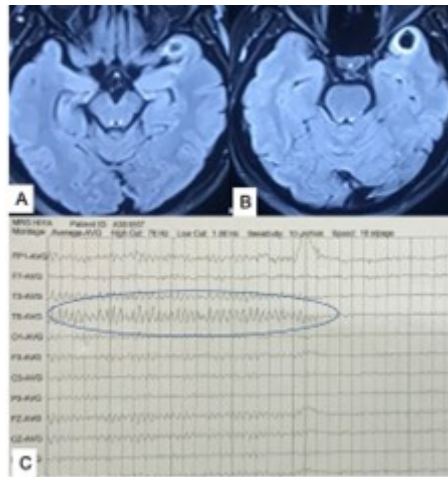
(A,B) MRI of brain axial views showing left temporal polar cystic lesion causing complex partial seizures. (C) Scalp EEG tracing showing left temporal focal discharges. Source: Figure by authors.
